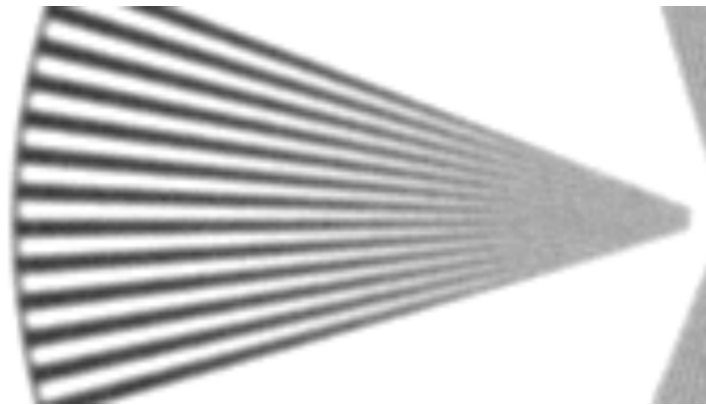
Star pattern acquired with too little radiographic magnification. It is difficult to unambiguously identify the center of the blur region.
